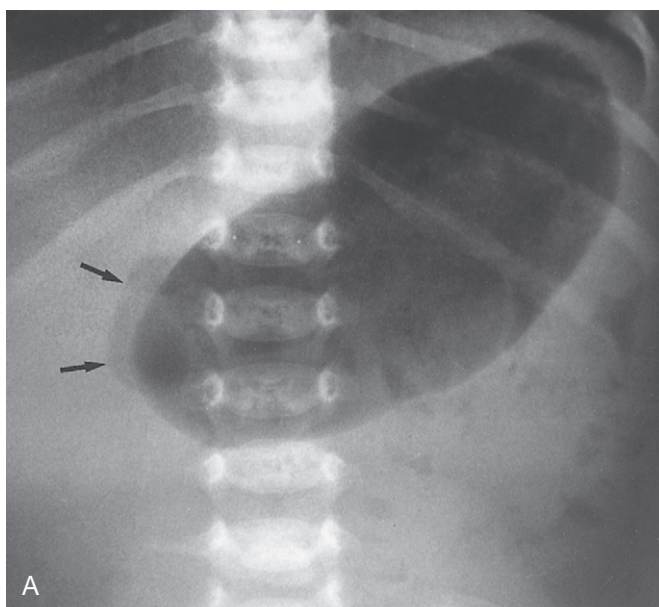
A, Plain radiograph of an infant with midgut volvulus. Obstruction of the descending duodenum may result in the pattern of gaseous distention of the stomach and duodenum (*arrows*) seen here, with a paucity of gas noted distally. B, Eight-day-old infant with midgut volvulus. This pattern of distal intestinal obstruction with thickened walls is much less common than that of proximal duodenal obstruction, but it is associated with more severe vascular compromise and clinical illness. (A, Courtesy Marc S. Keller, MD, Yale University School of Medicine.)
